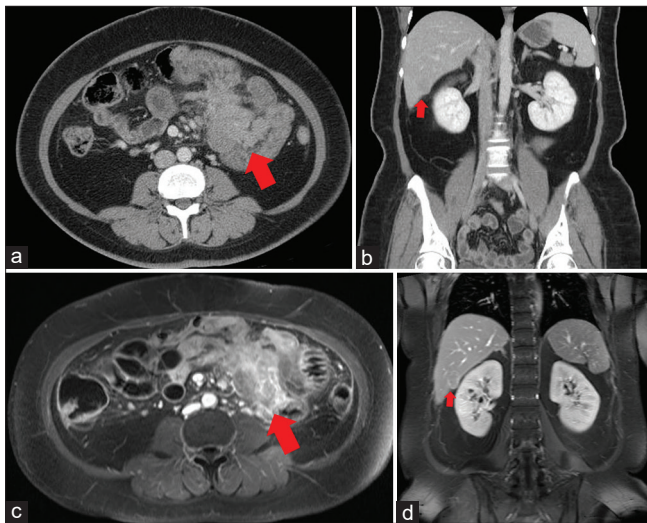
Contrast-enhanced CT and MRI of the abdomen and pelvis showed (a and c) an enhanced soft-tissue mass in the jejunum with enlarged regional lymph nodes; (b and d) a liver tumor at S6 (arrow). CT: Computed tomography, MRI: Magnetic resonance imaging
